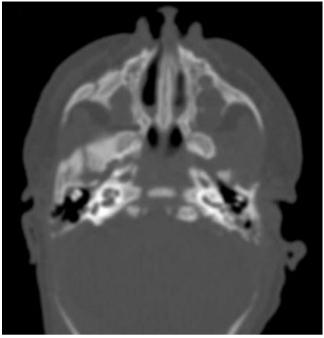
Axial computed tomography showing bony bilateral choanal atresia in an infant with CHARGE syndrome
